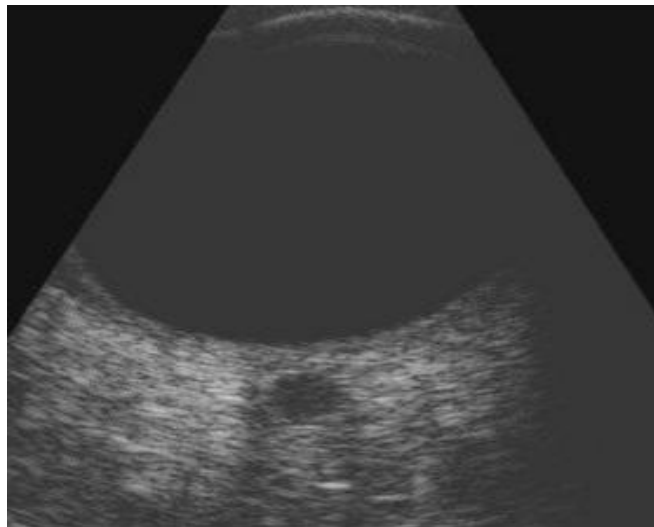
B-scan ultrasound picture showing an oval echolucent focus displayed just behind the globe indicating the cross section of the optic nerve.
